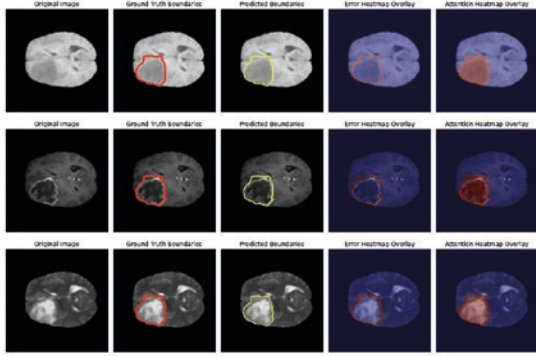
Segmentation examples for BraTS 2018 HGG: FLAIR, T1, T1CE, T2.
